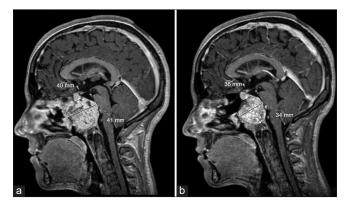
Comparison of the brain magnetic resonance imaging at diagnosis and 4 years later (a) Brain magnetic resonance sagittal T1 with Gadolinium, May 2020 (b) Brain magnetic resonance sagittal T1 with Gadolinium, May 2024.
